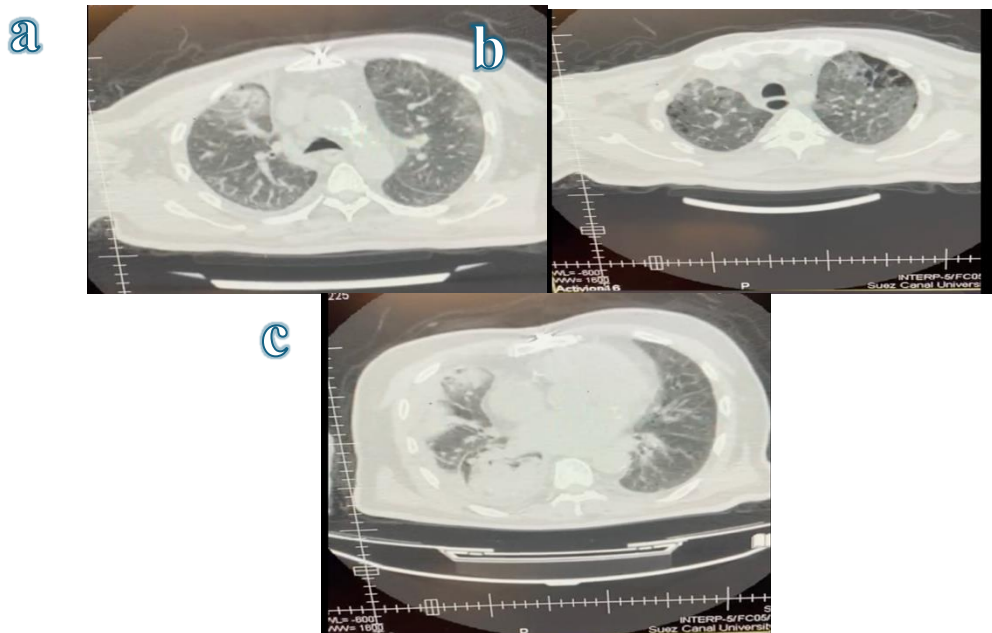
CT chest showed (a) Bilateral emphysematous changes and few GGOs, (b) There was a patch of consolidation on the upper lobe of the right lung, (c) There was mild to moderate pleural effusion with underlying consolidation vs collapse on the right side lower lobe. The total degree of tissue involvement in CT was approximately 70%.
